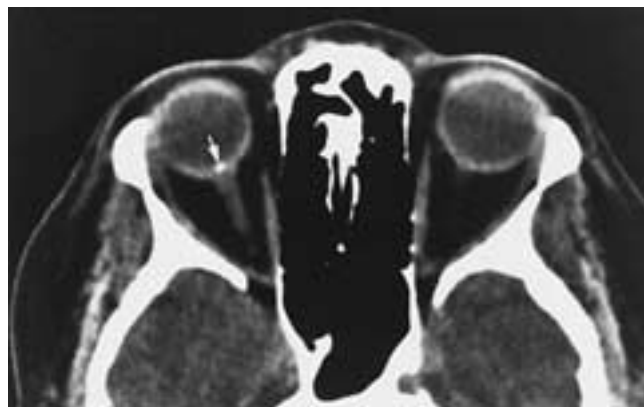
Optic nerve head drusen. Axial CT scan shows increased density at the optic disc (arrow).
